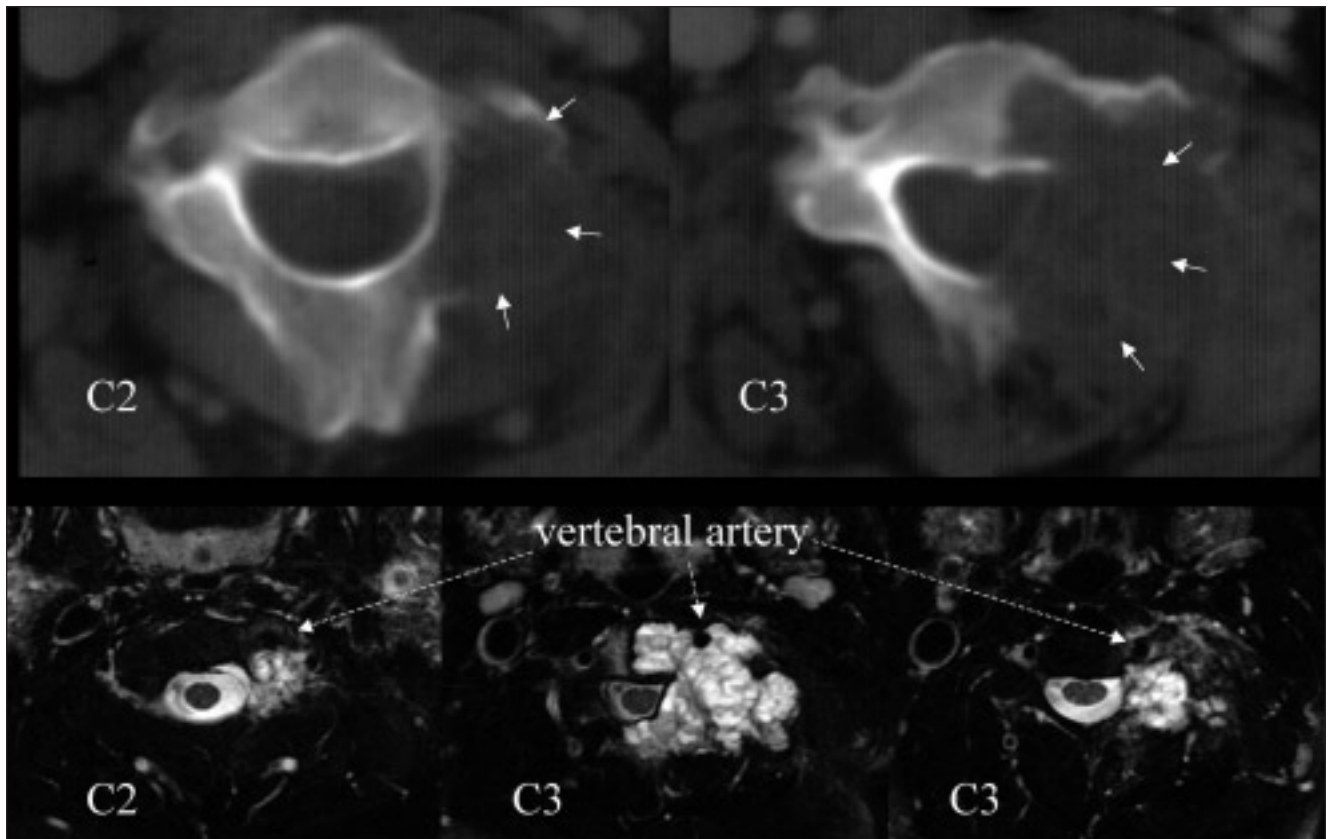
Top: On computed tomography the erosive nature of the tumour can be seen, destroying the left lateral aspect of C2 and C3. Invasion into the body of C3 is clearly seen. Bottom: Contrast-enhanced axial magnetic resonance images show encasement of the left vertebral artery by the tumour.
